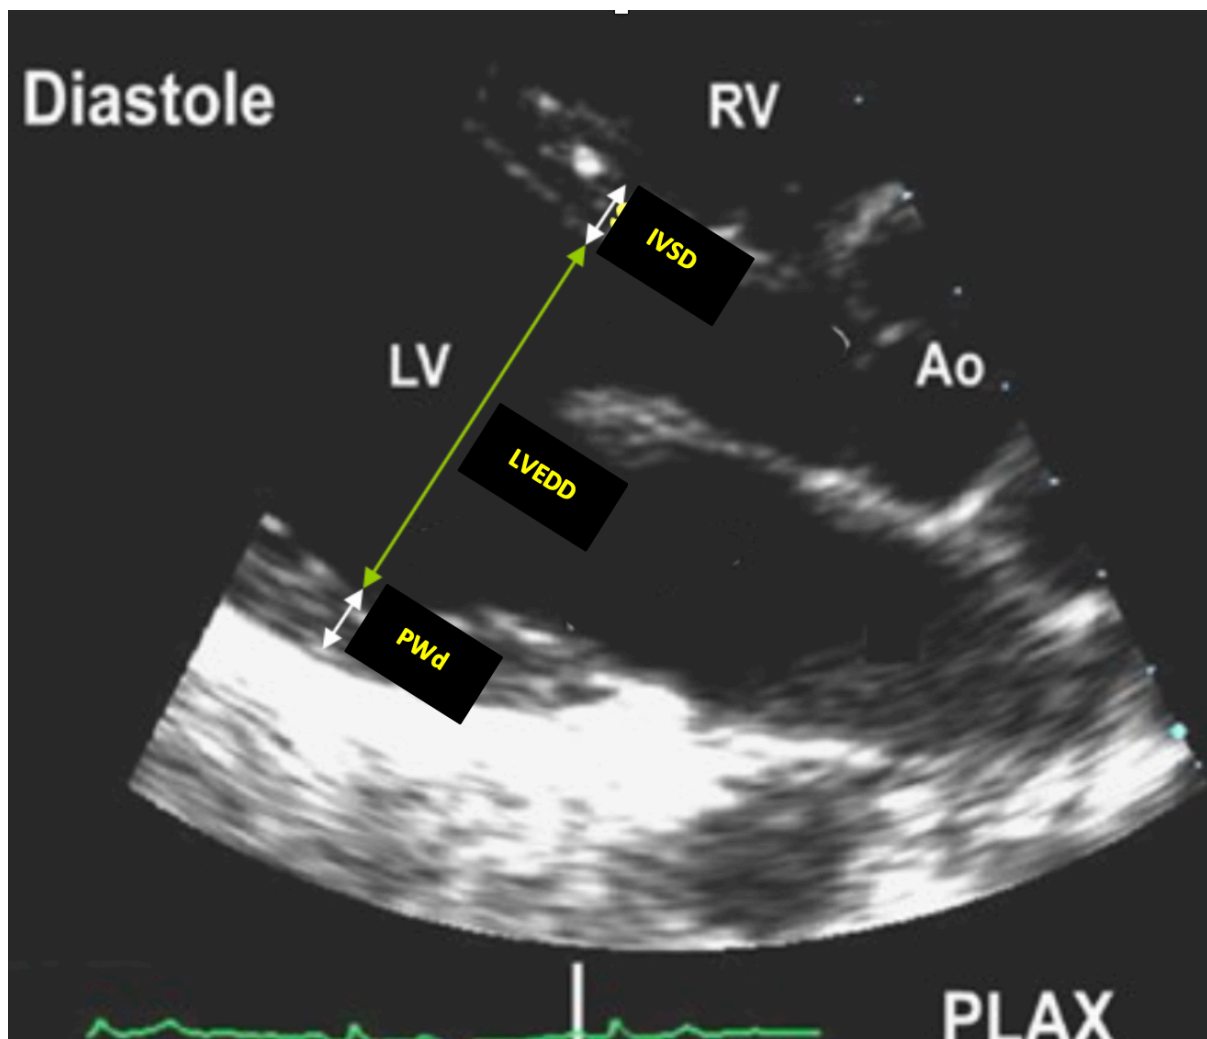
Measurement of LVEDd, IVSd, PWd from 2D echocardiography.
